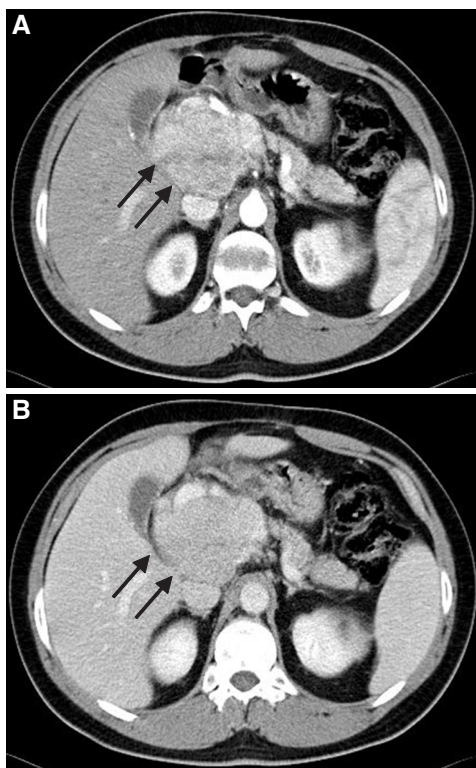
Computed tomography of axial planes in the arterial phase (A) and portal phase (B). Mass in the caudate lobe (arrows), non-capsulated, is identified in non-cirrhotic liver. Lesion presents heterogeneous enhancement in arterial phase (A) and late wash-out (B)
